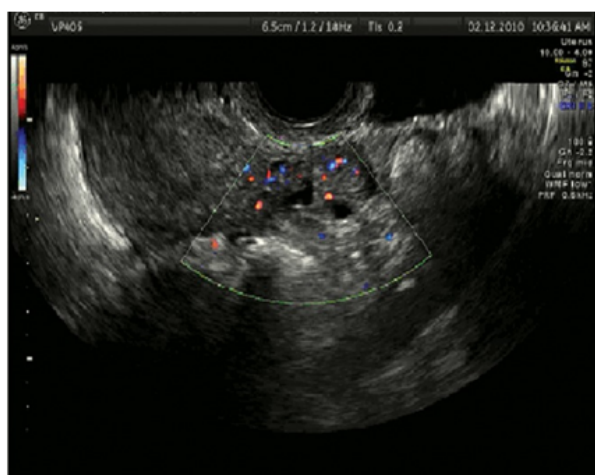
Ultrasound and peripheral vascularization.
